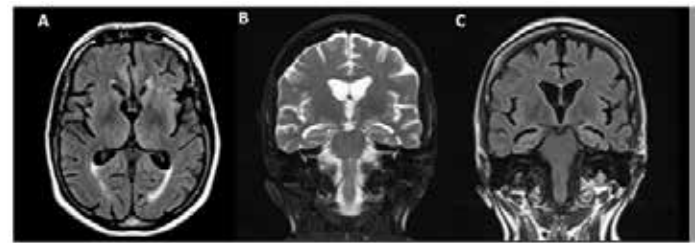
FLAIR axial (A and B) and T2-weighted coronal (C) brain MRI showing global brain volume reduction, predominantly in the mesial temporal lobe, characterized by increased volume of choroidal fissure and lateral ventricle temporal horn, with moderate hippocampal atrophy (circles in B and C) (Scheltens 3). There were also white-matter hyperintense signal, compatible with microangiopathy (Fazekas 2). An 80-year-old woman presenting a progressive amnesia started two years earlier. She did not remember recent events or where she placed objects. She also had poor speech with repetitive questions. At neurological examination, she had no focal neurological signs, however she obtained 22 points at the MMSE and 19 points at the MoCA, with impairment mainly in memory and visuospatial functions. Reversible dementias were ruled out after laboratory screening. These findings indicated AD as diagnosis, and donepezil was applied as treatment.
